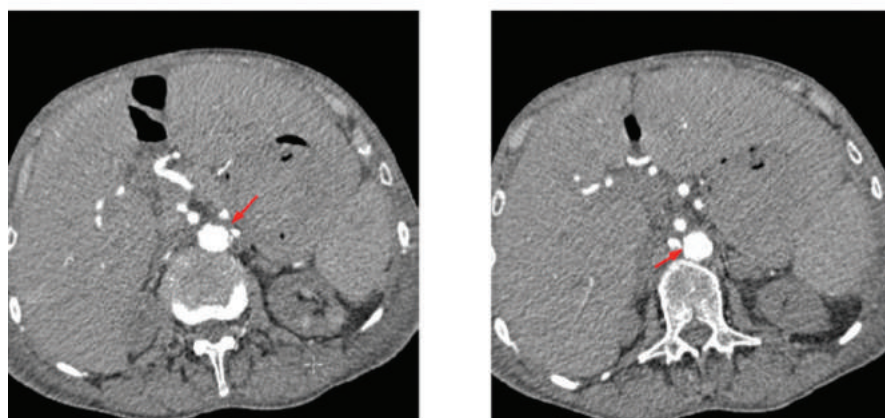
CT angiogram: severe stenosis at the origin of the left (a) and right (b) renal artery
